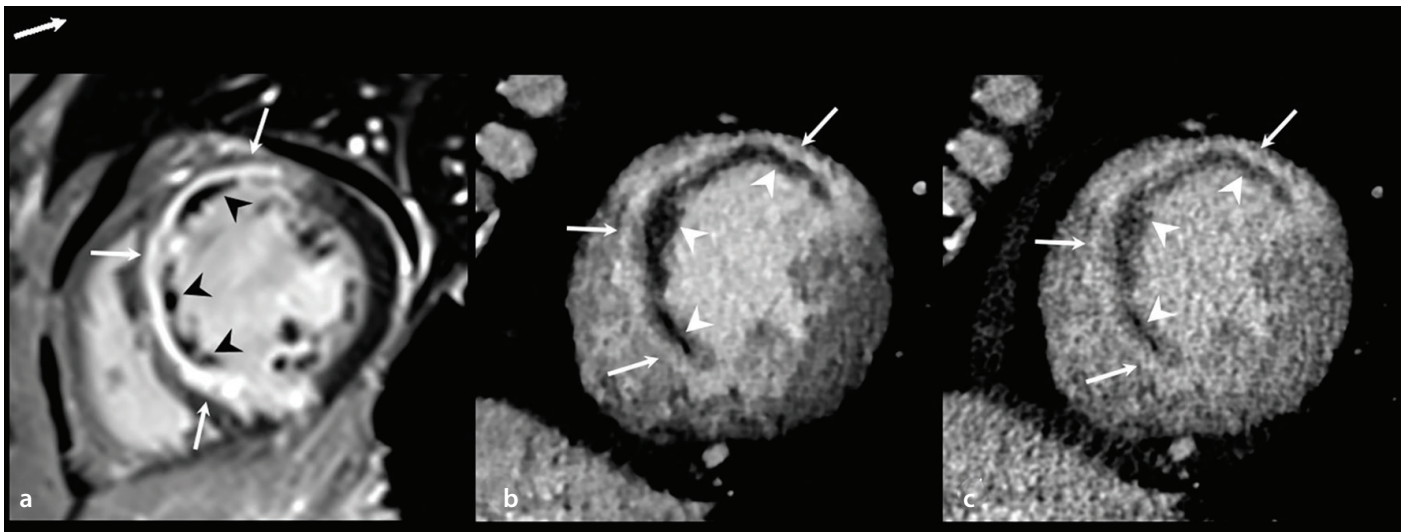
Short-axis MDE-CT images of a 64-year-old man with reperfused STEMI. (a): Short-axis LGE-CMR image demonstrates transmural delayed enhancement (arrows) with central non-enhancing areas consistent with MVO (arrowheads) involving the mid-anterior, anterolateral, anteroseptal, and inferoseptal LV segments. (b, c): Artificial intelligence-based, contrast-enhanced, and denoised CT image (b) shows reduced image noise and improved visualization of transmural delayed enhancement (arrows) and non-enhancing regions consistent with MVO (arrowheads) compared with the standard CT image (c). MDE, myocardial delayed enhancement; CT, computed tomography; STEMI, ST-segment elevation myocardial infarction; CMR, cardiac magnetic resonance; LV, left ventricular; LGE, late gadolinium enhancement; MVO, microvascular obstruction; AI, artificial intelligence.
